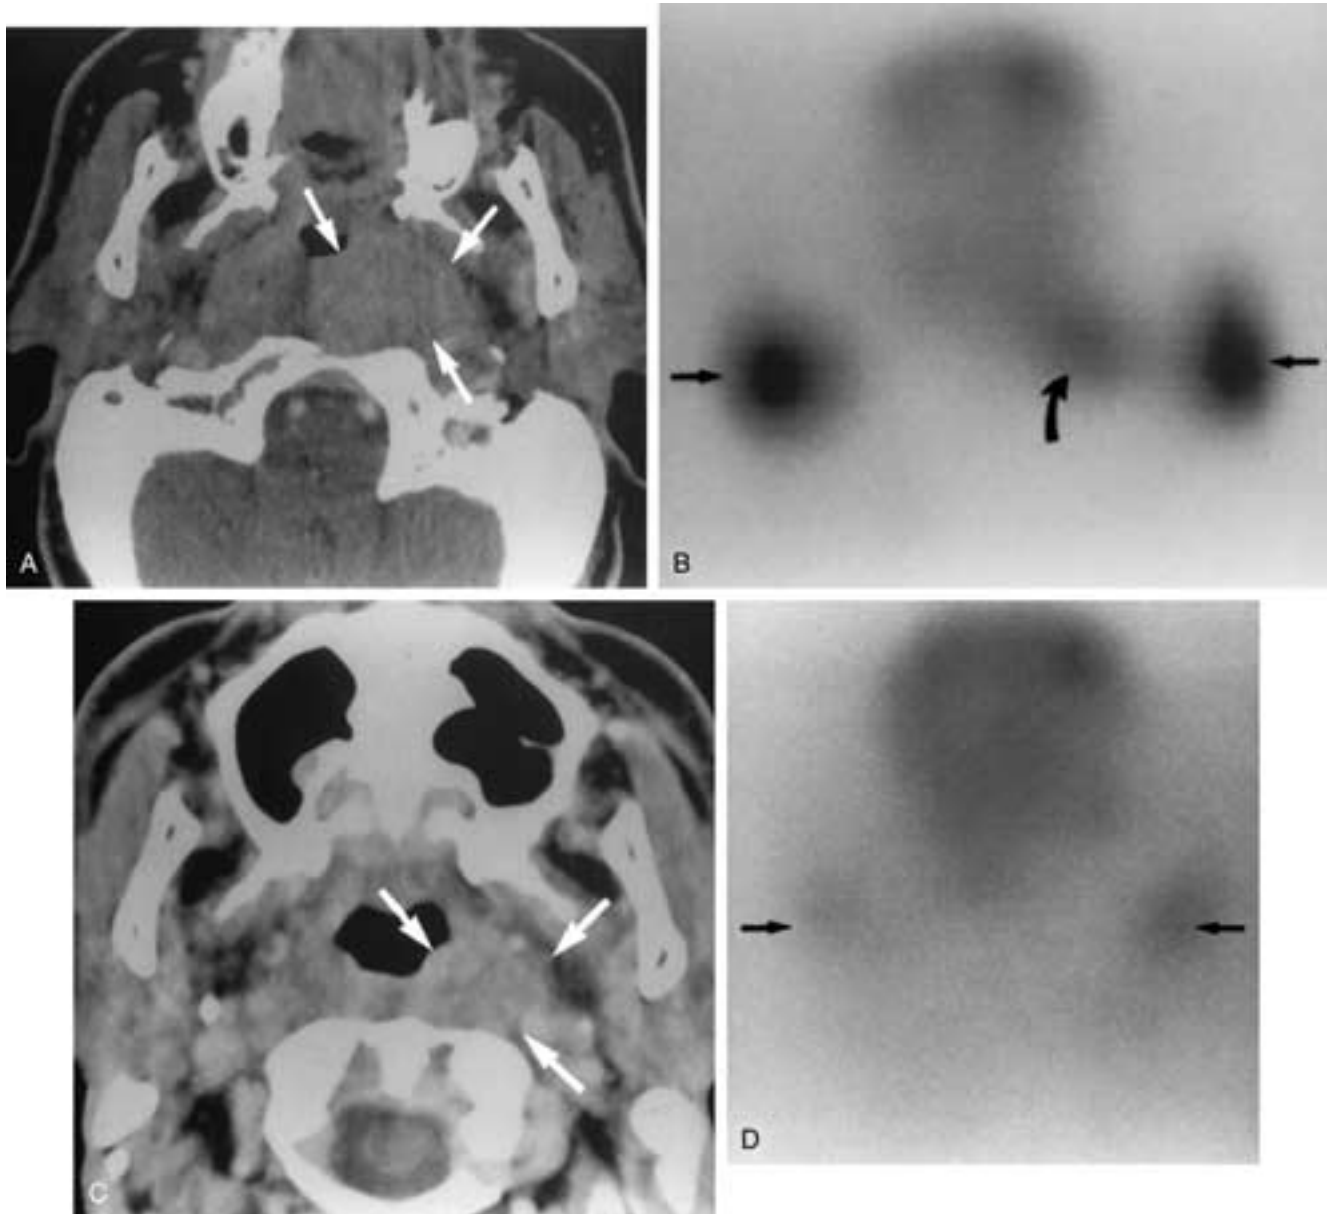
Successful local control following nonsurgical organ preservation therapy. A, Axial pretreatment contrast-enhanced CT image demonstrates an SCC involving the left side of the nasopharynx (*arrows*). B, Axial image from a pretreatment thallium-201 SPECT scan obtained at approximately the same level as A shows an area of abnormal radiotracer uptake corresponding to the abnormality seen on CT (*curved arrow*). Normal parotid gland uptake (*small arrows*). C, CT scan performed 6 weeks after completion of treatment demonstrates a persistent mass in the region of the primary site (*arrows*). D, Posttreatment thallium study obtained at approximately the same level as C shows no abnormal radiotracer uptake 6 weeks after completion of therapy. This patient had no evidence of recurrent disease at the primary site 2 years after completion of treatment. Note the reduction in parotid gland uptake following treatment (*arrows*). (From Mukherji SK, Gapany M, Neelon B, et al. Evaluation of ^{201}Tl SPECT for predicting early treatment response in patients with squamous cell carcinoma of the extracranial head and neck treated with nonsurgical organ preservation therapy: Initial results. *J Comput Assist Tomogr* 2000;24:146-151.)
